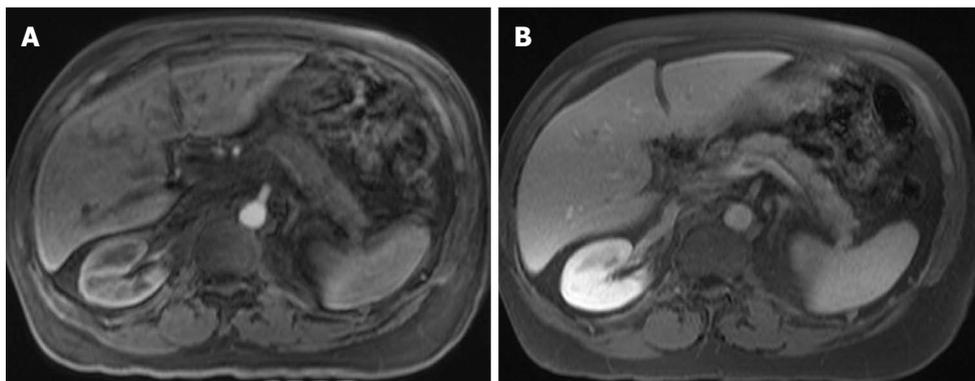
Chronic pancreatitis. A: Axial post-Gadolinium 3D-GRE T1-weighted image with fat-suppression during the hepatic arterial-dominant phase; B: Axial post-Gadolinium FLASH in-phase T1-weighted image with fat-suppression during the hepatic-venous phases. The pancreatic body and tail show poor early contrast enhancement (A) and mild enhancement on the delayed images related to fibrosis (B) in keeping with chronic pancreatitis.
